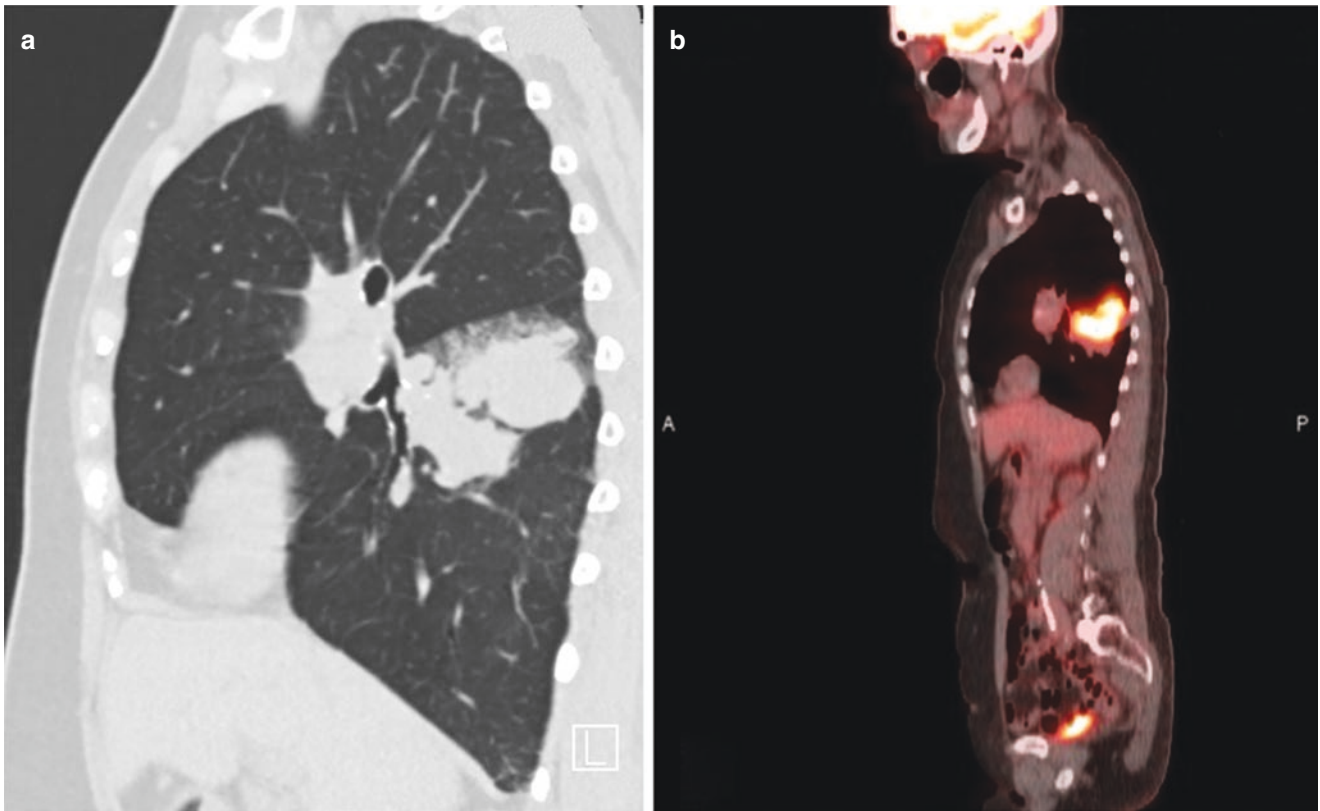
Chest CT image shows a mass in the right lower lobe and a mass in the right hilum (a), which are hypermetabolic in PET scan (b)
